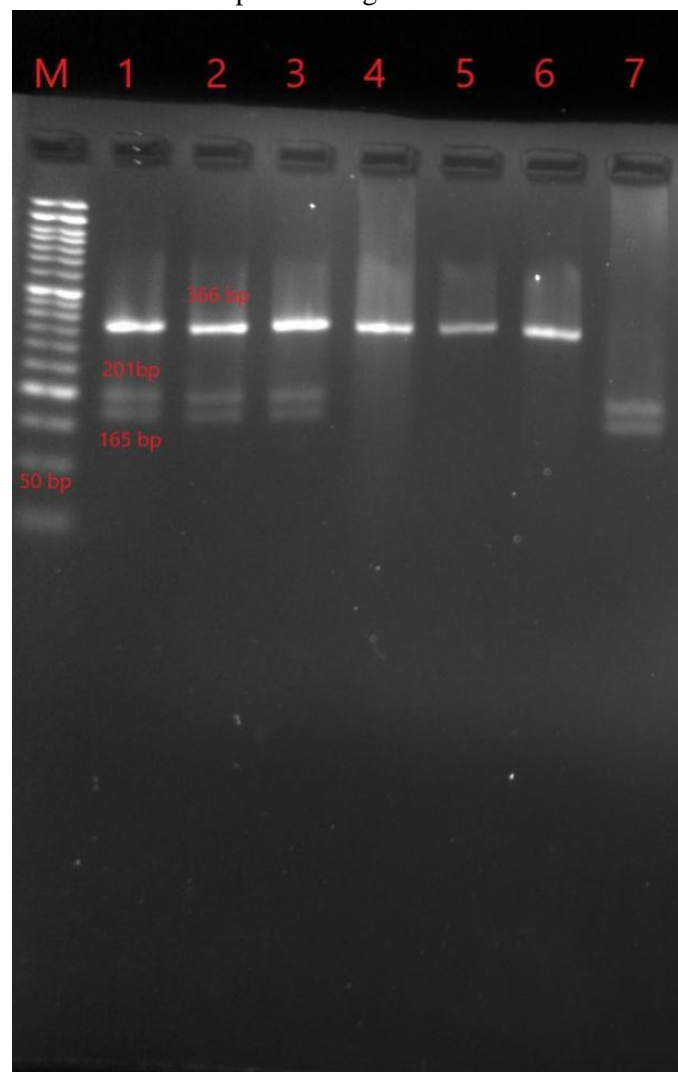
PCR RFLP analysis c.742C>T polymorphism in the of Fetuin A. Lane M: 50 bp marker; Lanes 1,2,3: CT alleles ;Lanes 4,5,6: CC alleles ; Lanes 7:TT alleles
